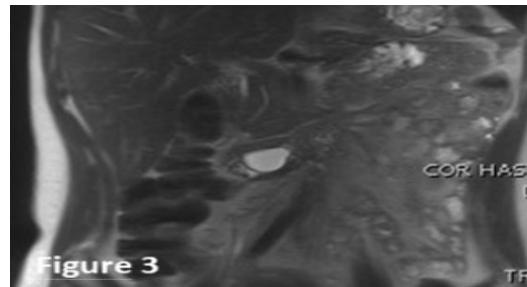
MRI showing the large cyst in the 2nd portion of the duodenum that appears to be separate from the biliary tree and pancreas
